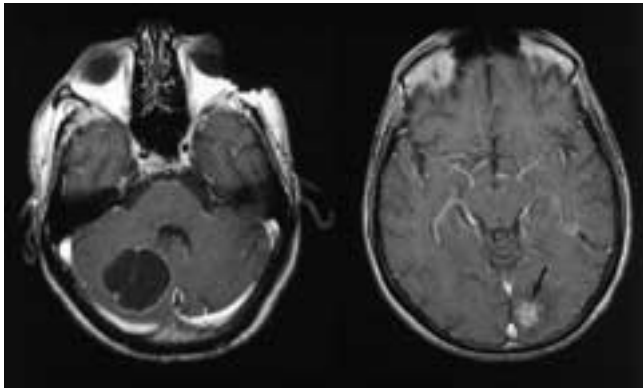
Hematogenous metastases. A 48-year-old male presented with a 3-month history of 40-pound weight loss, chronic cough, malaise, and drenching night sweats. A 5 cm diameter poorly differentiated SCC with necrosis was discovered in his distal trachea. T1-weighted postgadolinium MR image through the posterior fossa demonstrates a 3.5 cm diameter cystic mass with ring enhancement and internal septation. There is a slight mass effect on the fourth ventricle (left). Axial T1-weighted postgadolinium image at a more superior level (right) demonstrates an enhancing mass in the left occipital lobe (*large arrow*) with surrounding edema, as well as a small enhancing mass in the medial left temporal lobe (*small arrow*).
